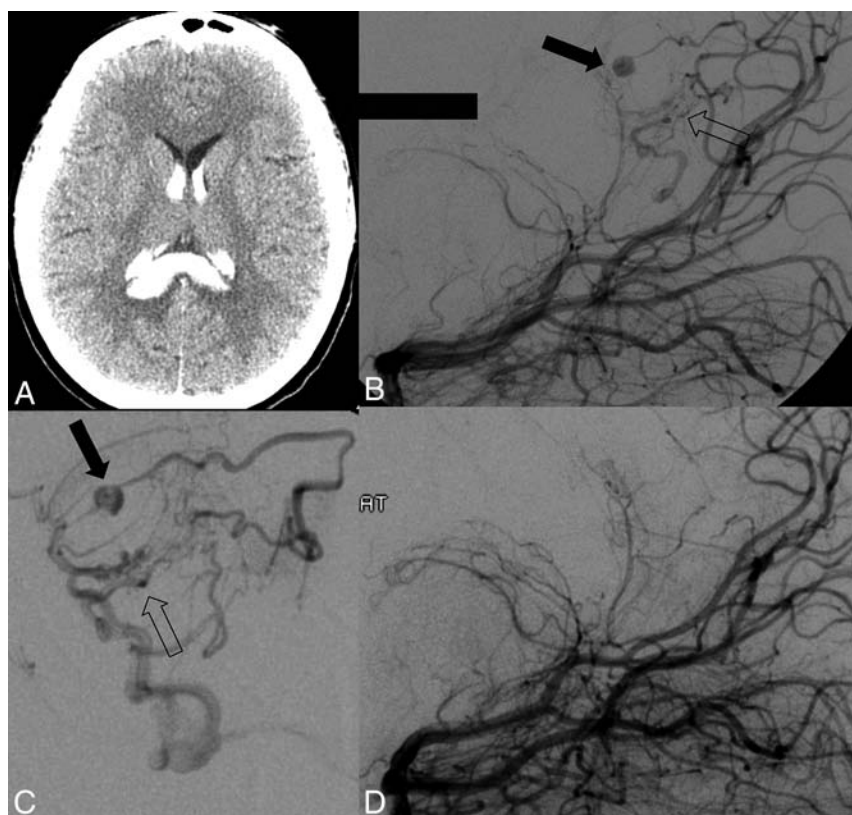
Ethanol sclerotherapy of a feeding artery aneurysm in a 15-year-old girl presenting with headache. A, Noncontrast CT head axial image demonstrates acute intraparenchymal hemorrhage centered in the splenium of the corpus callosum with intraventricular extension. B, Selective injection of the left vertebral artery in a reverse Schuller projection demonstrates a small AVM nidus (open arrow) and a 5-mm feeding artery aneurysm arising from the right splenic artery (black arrow). C, Lateral view of a superselective microcatheter injection of the right splenic artery. The AVM nidus (open arrow) and a 5-mm feeding artery aneurysm (black arrow) are again seen. D, Twenty minutes after ethanol sclerotherapy with 4 mL of 70% ethanol, posttherapy reverse Schuller projection of a left vertebral artery injection demonstrates the absence of the feeding artery aneurysm and AVM nidus and no evidence of arteriovenous shunting.
